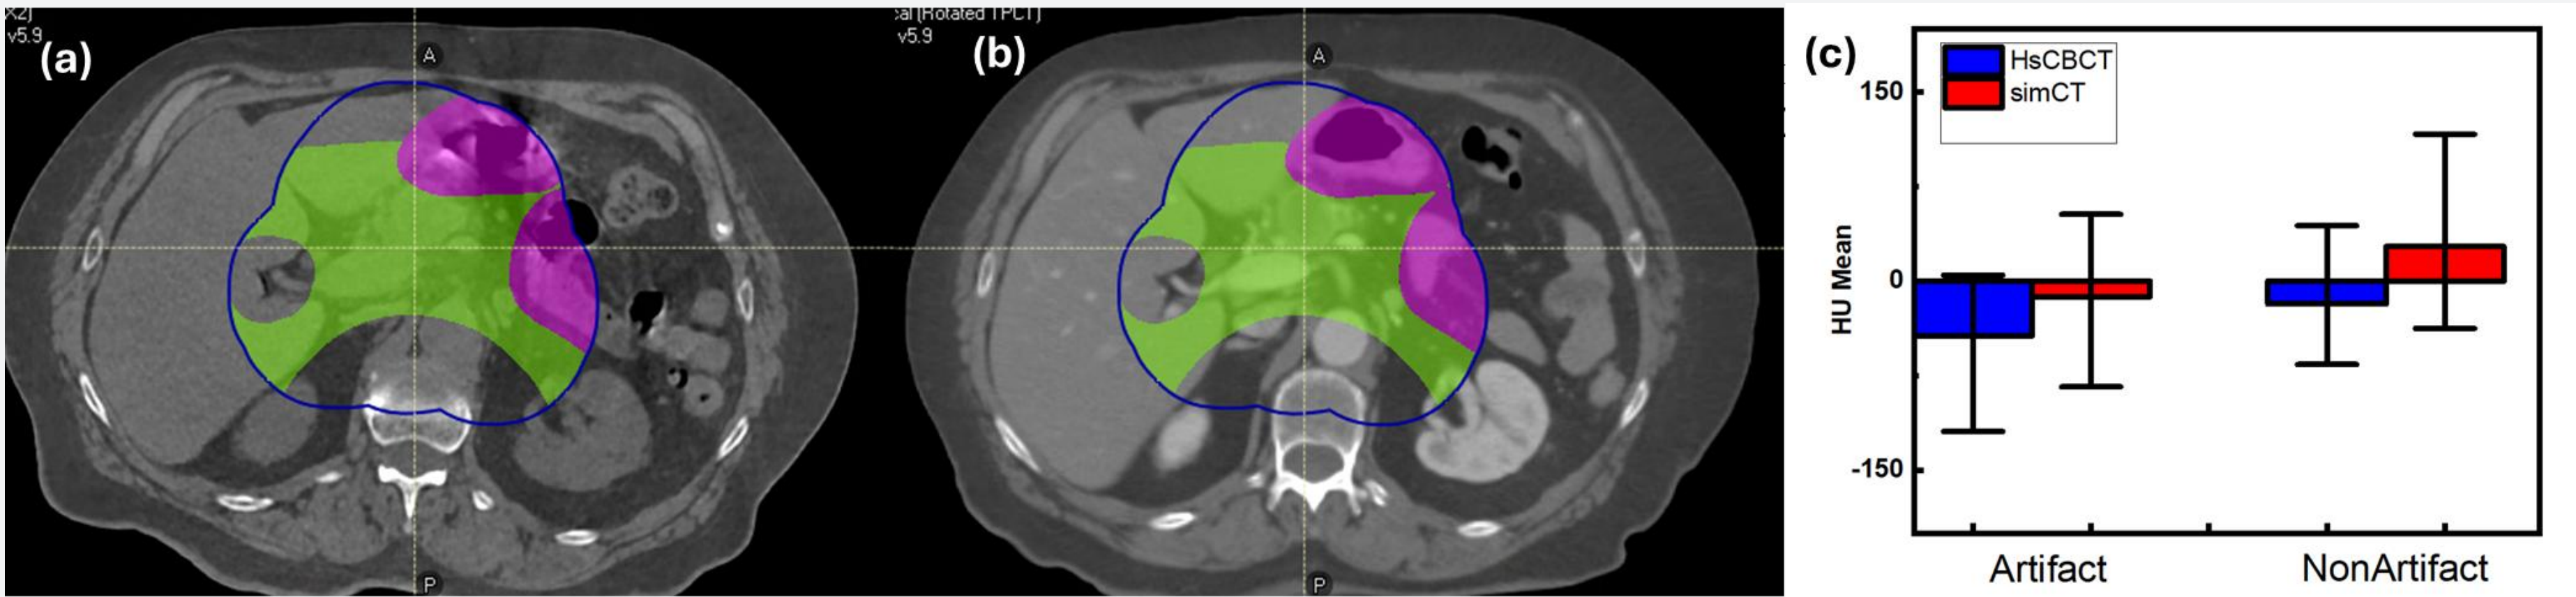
Artifact regions (red) and non-artifact regions (green) are defined on HsCBCT and simCT. Box-and-whisker plots summarize HU mean differences in artifact and non-artifact regions.
